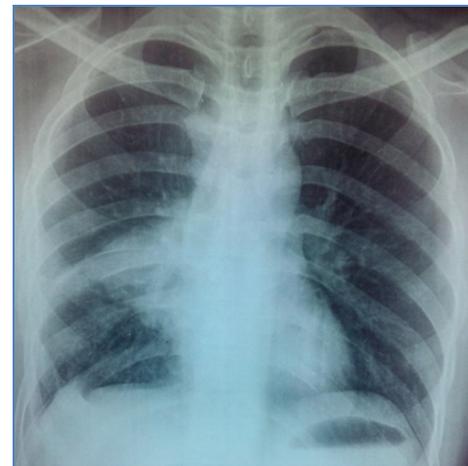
Chest x-ray PA-3 (post treatment)
